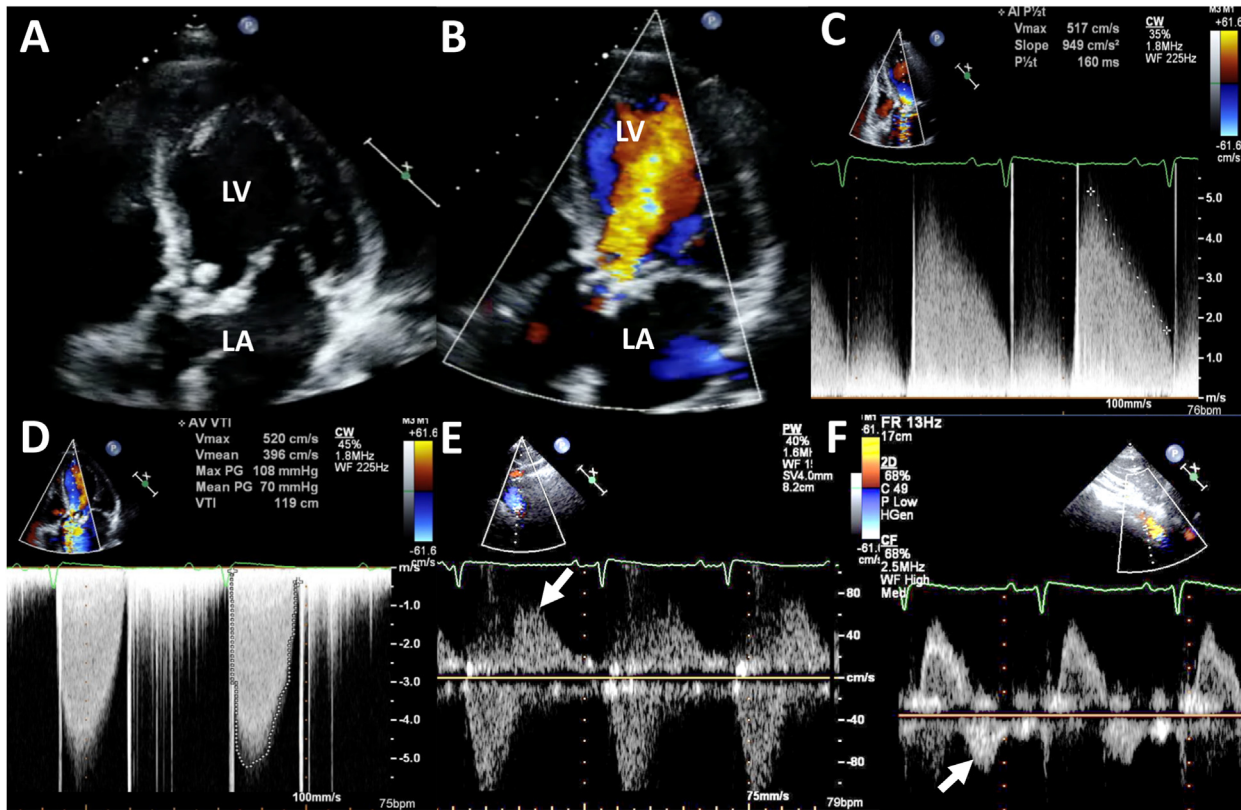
An example of combined AR and stenosis in a patient with a tissue prosthetic aortic valve (AV). (A) TTE in the apical five-chamber view during diastole demonstrates a vegetation on the tissue prosthetic AV. (B) The corresponding color Doppler image demonstrates severe regurgitation. (C) On the CW Doppler image, the PHT is <200 msec, which is consistent with severe regurgitation. (D) A high systolic gradient across the valve is evident. (E) PW Doppler in the proximal descending thoracic aorta demonstrates flow reversal (*arrow*). (F) Flow reversal is also seen in the abdominal aorta (*arrow*). LA, Left atrium; LV, left ventricle; Max, maximal; PG, pressure gradient; Vmax, maximal velocity; Vmean, mean velocity.
